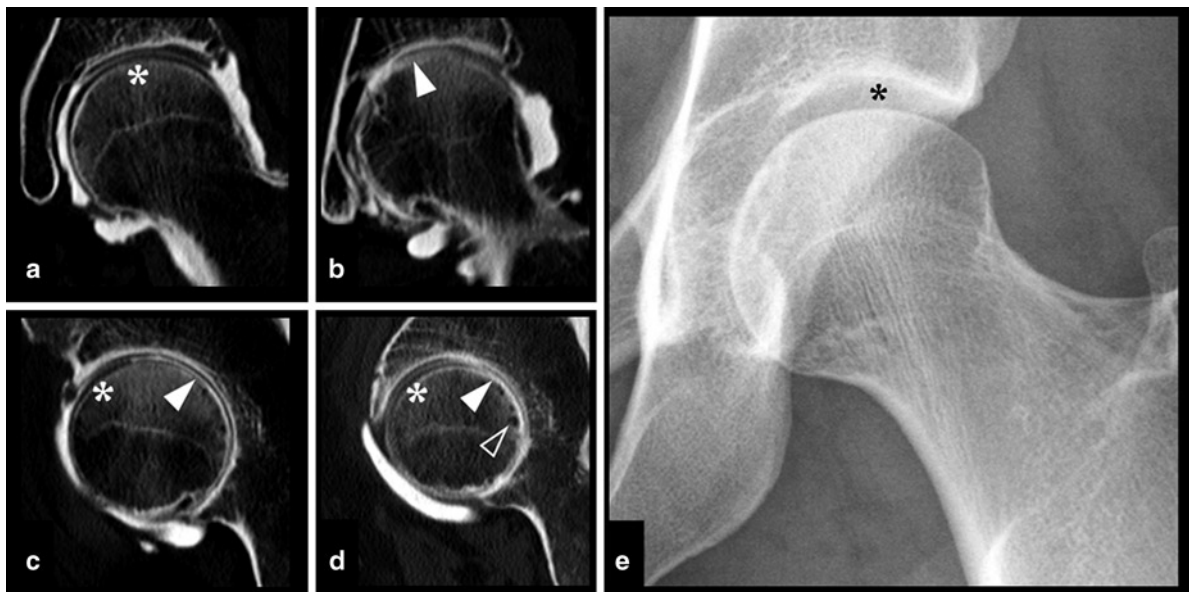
(a–e): (a–d) Computed tomographic (CT) arthrography of a 69-year-old woman with left hip pain. (a) Anterior and (b) posterior coronal reformats and (c, d) sagittal reformats show no significant damage to the antero-superior portion of femoro-acetabular cartilage (*white asterisks*), where an increasing cartilage thickness gradient exists from
